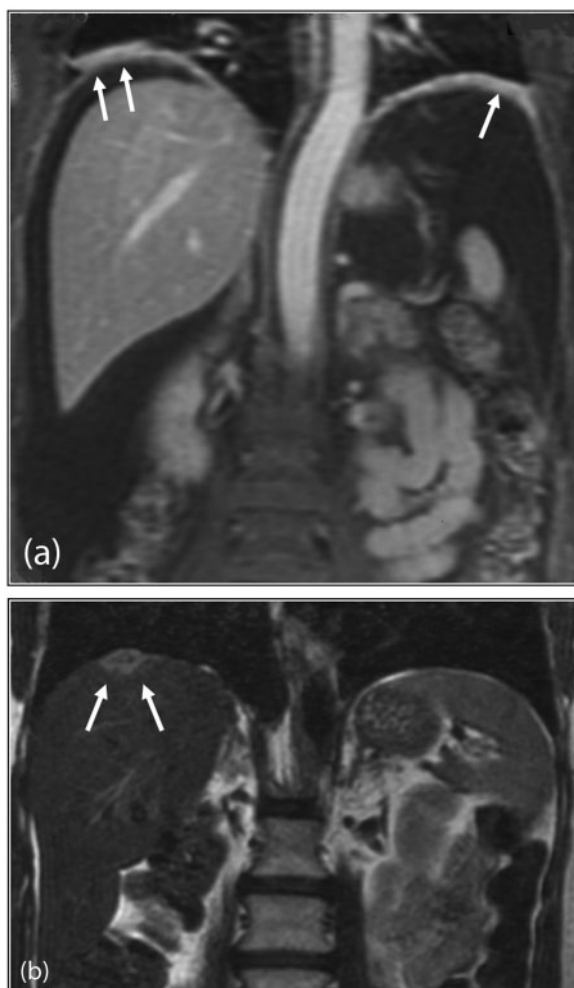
Subphrenic peritoneal disease. (a) Postgadolinium T1-weighted coronal MRI demonstrates nodular enhancement of bilateral subphrenic peritoneal deposits (arrows). (b) Coronal T2-weighted MRI of the upper abdomen shows a solitary right subphrenic deposit (arrows).
